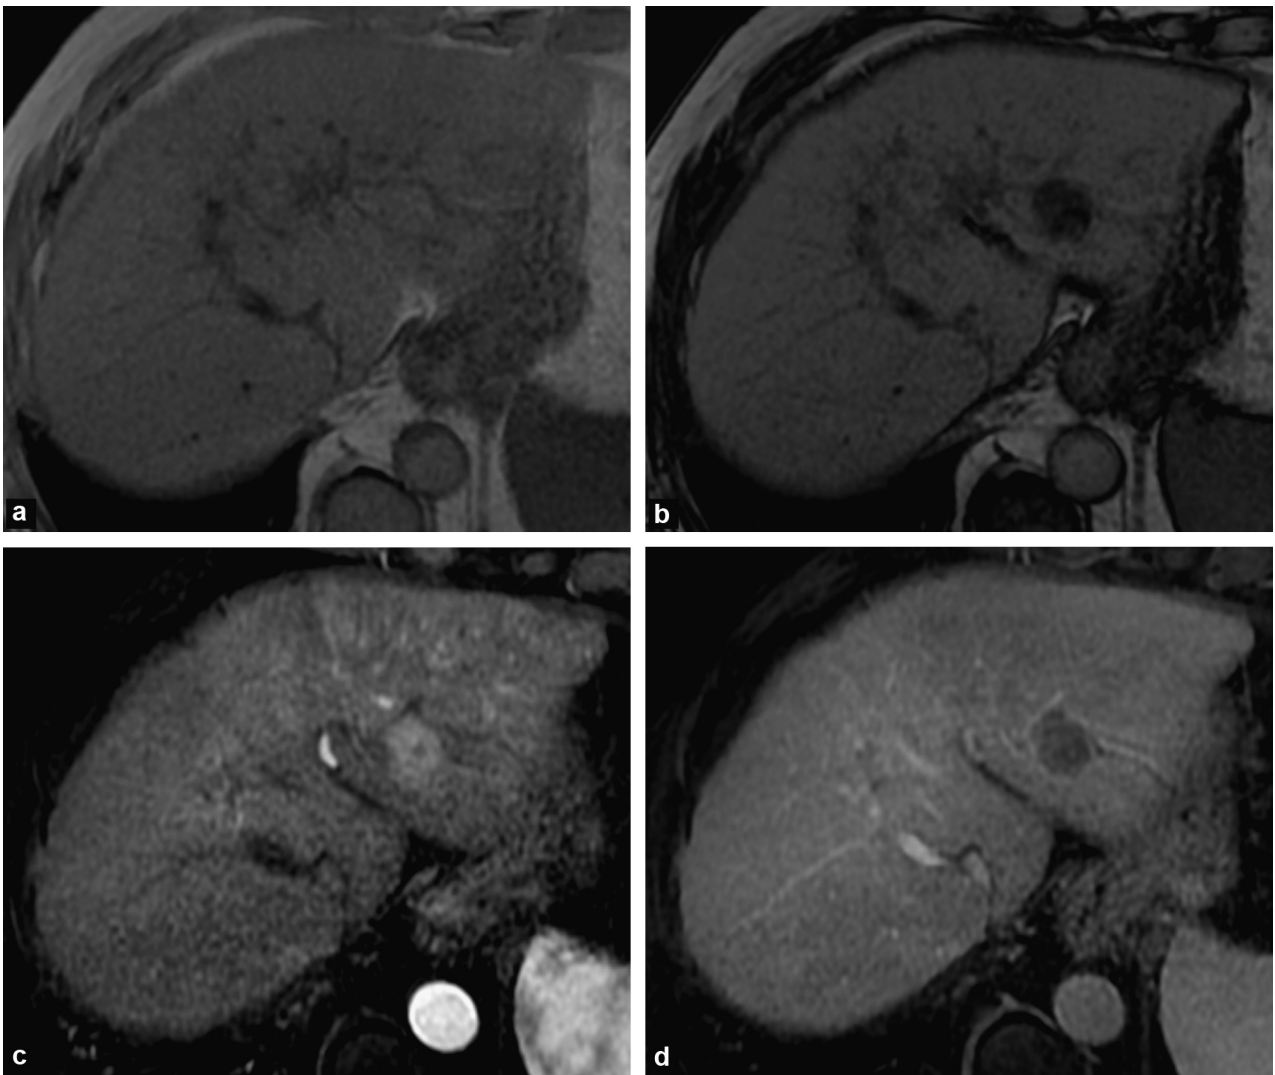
Hepatocellular carcinoma with a fatty component. Monitoring examination for cirrhosis of metabolic origin. T1-weighted MRI in phase (a) and out of phase (b): out-of-phase fall in signal indicating its fat content. T1-weighted image with fat saturation after gadolinium injection in the arterial (c) and portal (d) phases: enhanced in the arterial phase with lesion washout accentuated by the fat content.
